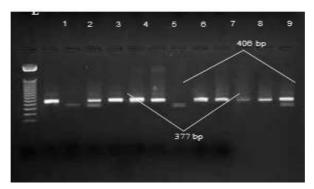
The 2% Agarose Gel Electrophoresis Showing the Restriction Digestion Patterns of Thr399Ile Polymorphisms of TLR4 Gene using Hinf I Enzyme. L: DNA Ladder. Lanes 1, 4, 9: Heterozygous Genotype (CT). Lane 2, 3, 5, 6, 7, 11, 12: Homozygous Wild Type (CC). Lanes 8, 10: Homozygous Mutant Type (TT)
